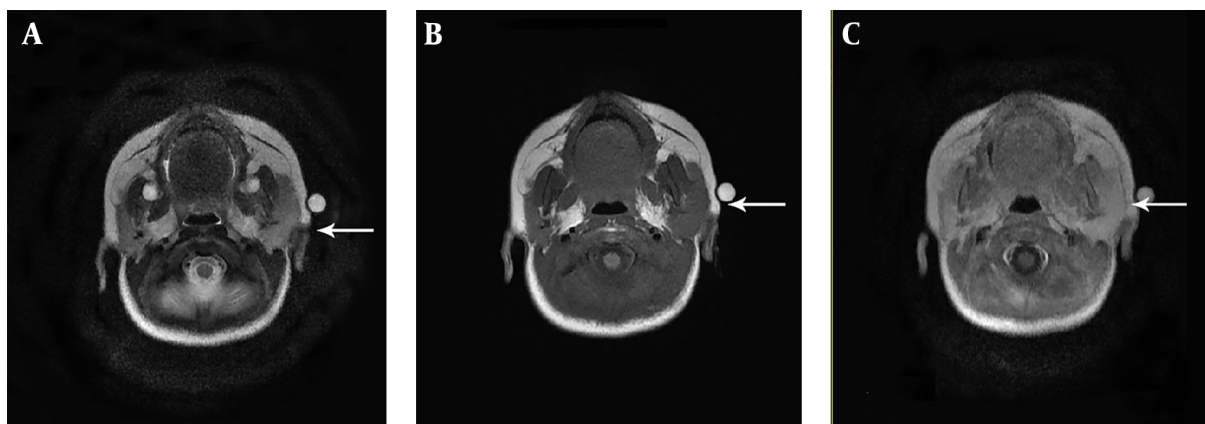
Cervical magnetic resonance imaging; axial views; enlargement and increased enhancement of the left parotid gland were determined by clinical history of acute parotitis; no collections or abscesses in the parotid space and no obvious stones or ductal dilatation were observed; left lymphadenopathy was found as two nodes; A, T2-weighted sequence; B, T1-weighted sequence; C, T1 IDEAL +C sequence
